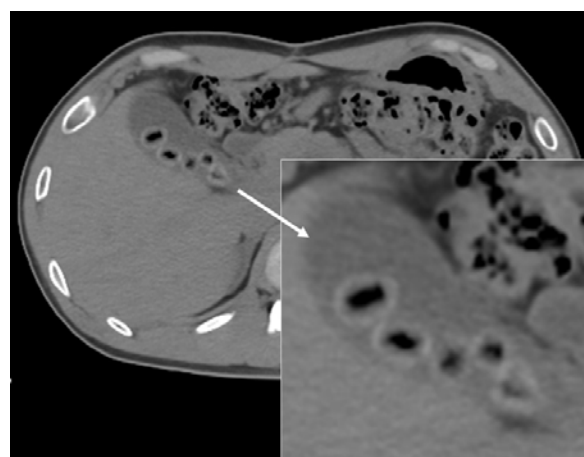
Abdominal computed tomographic image (CT)
